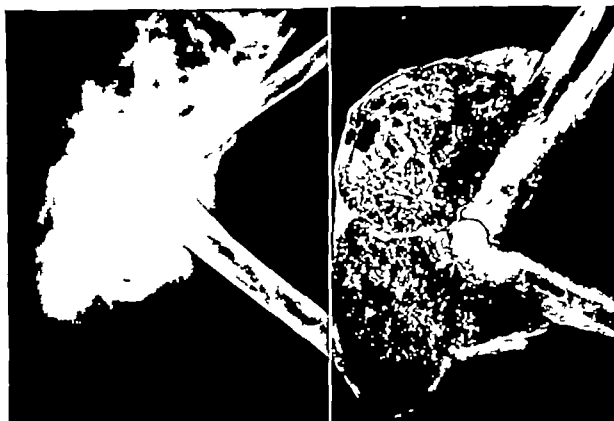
Roentgenogram of an aneurysmal bone cyst in the region of the elbow. Functional disability forced resection.
